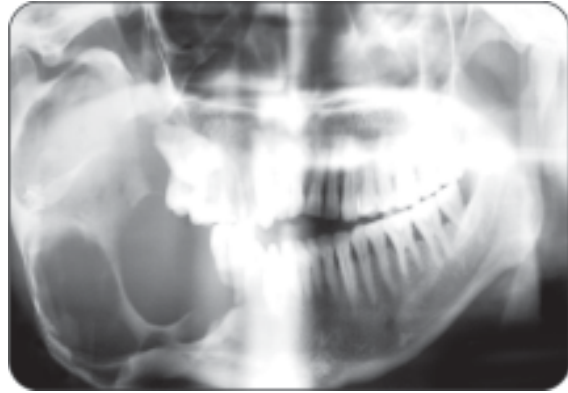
Radiograph of ameloblastoma-III
